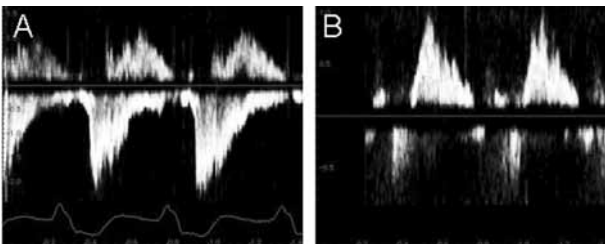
Pulse-wave doppler analysis showing a major systolic reversal flow in the upper left pulmonary vein (A) and no systolic reversal flow in the upper right pulmonary vein (B).
